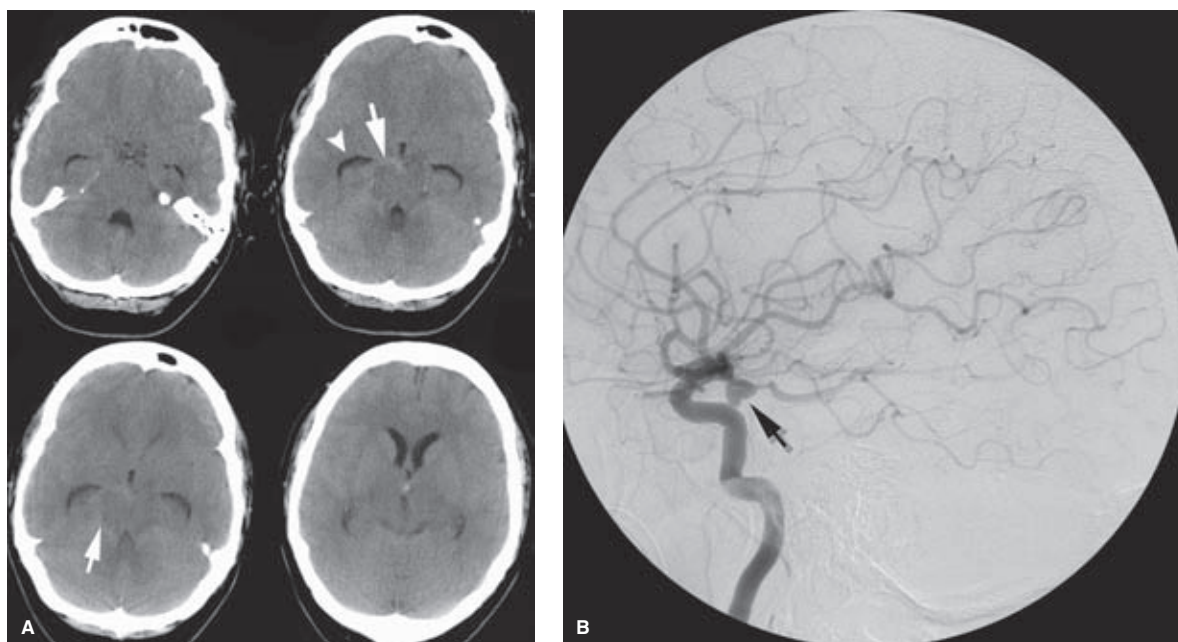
(A–B) Aneurysm in the setting of apparent perimesencephalic bleed. A young adult presented with very mild symptoms and a CT scan (A) showing a very typical appearance of perimesencephalic bleeding (arrows) and mild hydrocephalus (arrowhead). However, the angiogram (B) shows an irregular aneurysm of the right posterior communicating artery with lobulation of the dome (arrow), representing either an indentation of the tentorium on the dome or the presence of a ruptured daughter sac. The perimesencephalic pattern of subarachnoid hemorrhage on CT cannot be relied on to preclude the need for further investigation.
